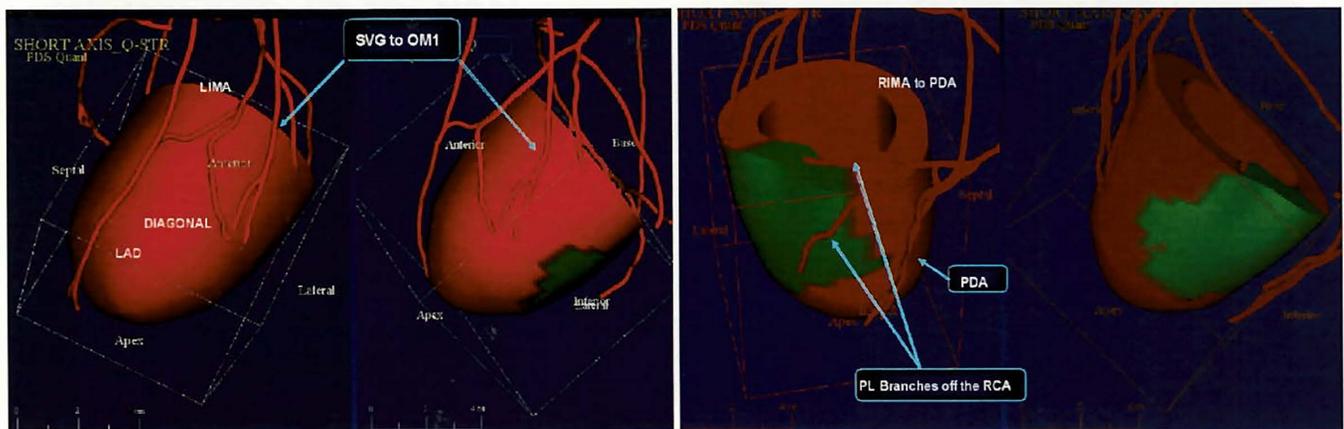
Example of CT-SPECT fusion imaging showing an ischemic inferolateral wall served by posterolateral branches from the RCA. IMA = internal mammary artery; L = left; OM1 = first obtuse marginal; R = right; SVG = saphenous vein graft. Other abbreviations as in previous figures.
